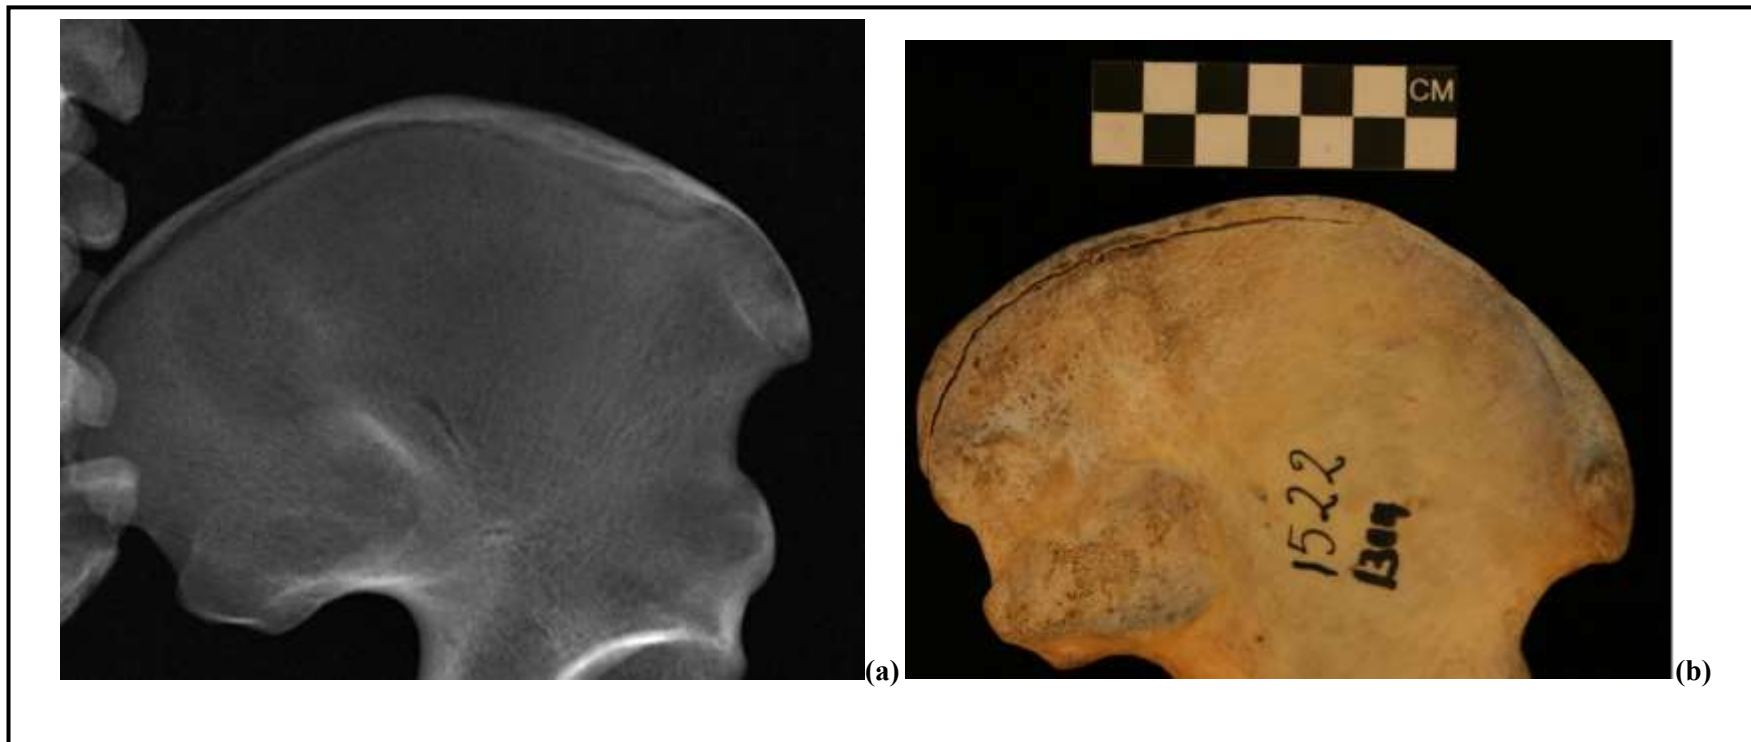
Radiographic and gross examination of the iliac spine. (a) The iliac spine greater than 50% union and thus scored as stage 3, incomplete union may still be observed on the anterior surface of the ilium along the margins. (b) Upon gross examination greater than 50% union is visible at the margins of the epiphysis (stage 3). It however appears as if the anterior iliac spine is slightly ahead that of the posterior iliac spine.
